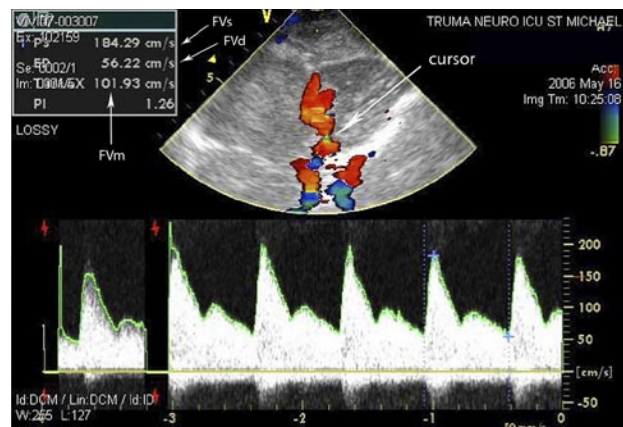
Transcranial colour-coded duplex sonography image of the basal cerebral circulation in the axial plane. During transcranial Doppler investigation, the cursor is moved along the target artery to find the highest flow velocity (top). Pulsed wave Doppler of the middle cerebral artery (MCA) at the point where the cursor is positioned (bottom). Systolic (FVs), diastolic (FVd), mean (FVm) flow velocity, and pulsatility index (PI) at top left of the screen.
